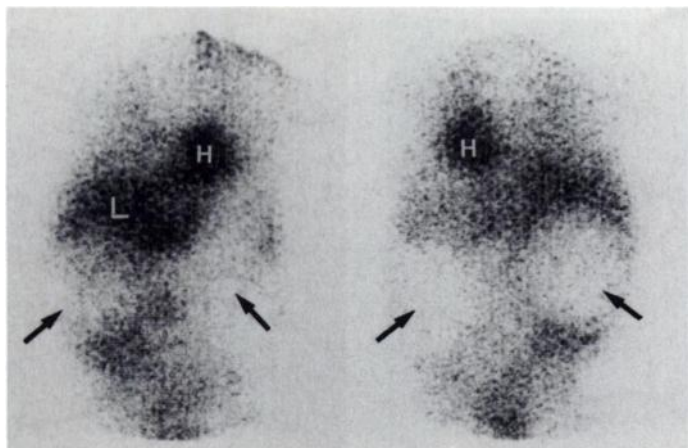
Anterior and posterior ^{131}I -MIBG scintigrams (10 min acquisition time) of chest and abdomen 24 hr after injection of 0.5 mCi shows absent tracer uptake in large bilateral Wilms' tumors (arrows). H = heart uptake; L = liver uptake.
